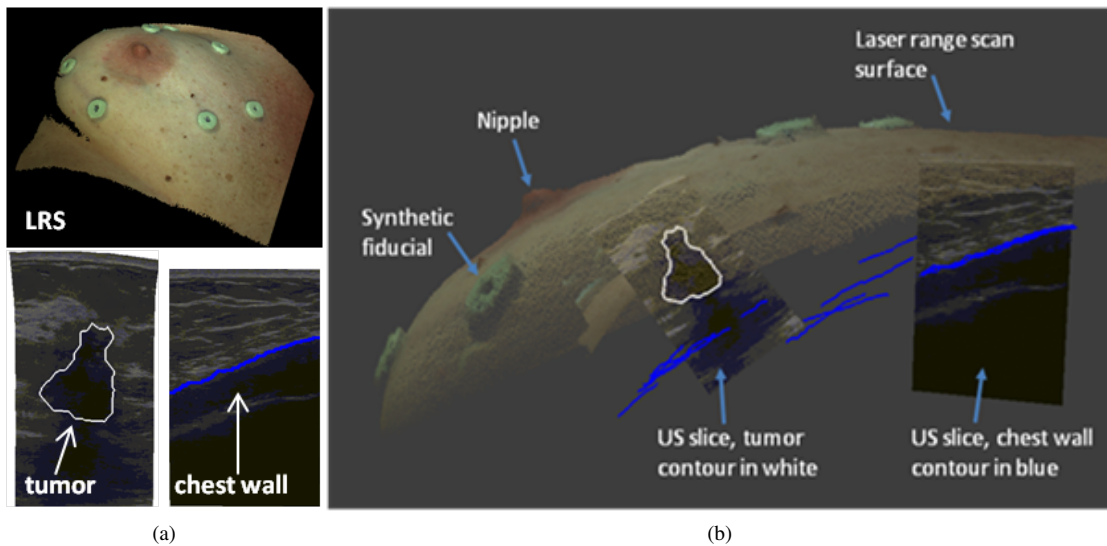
5: (a) Top: LRS scan of patient 2 breast. Bottom left: compression corrected ultrasound image with tumor contour in white. Bottom right: ultrasound image with chest wall contour in blue. (b) Fusion display of tracked intraoperative data containing a textured point cloud, adhesive fiducial markers, tracked ultrasound images, tumor contour (white), and chest wall contours (blue).
